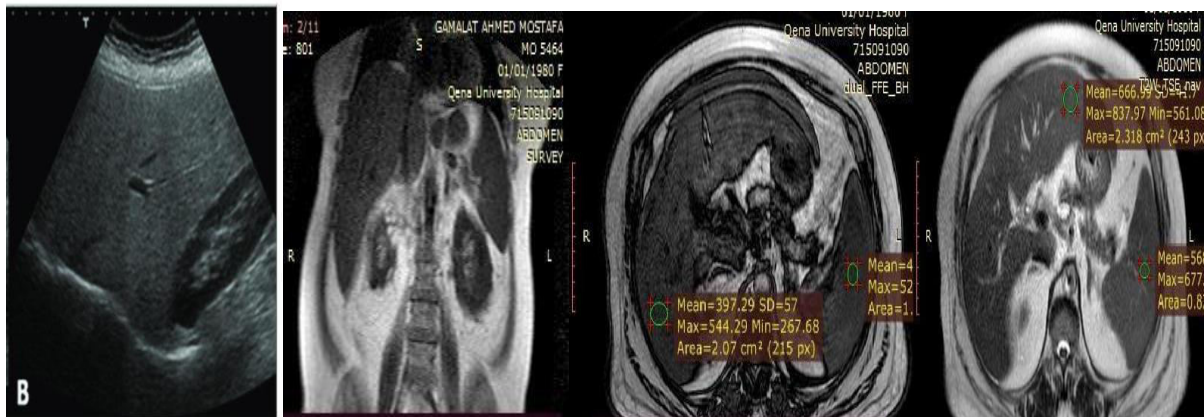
A 40-year-old male diabetic patient whose BMI was 30 kg/m² presented with right hypochondrial pain. Liver enzymes were normal., SGPT=30 U/L, SGOT 25 U/L, total bilirubin 0.55 mg/dl, abdominal ultrasound showed mildly enlarged diffuse fatty liver grade I, MRI shows Mildly hyper intense signals on T1, Hypo intense signals on both T2, and out phase With Liver Steatosis \pm 21.8
